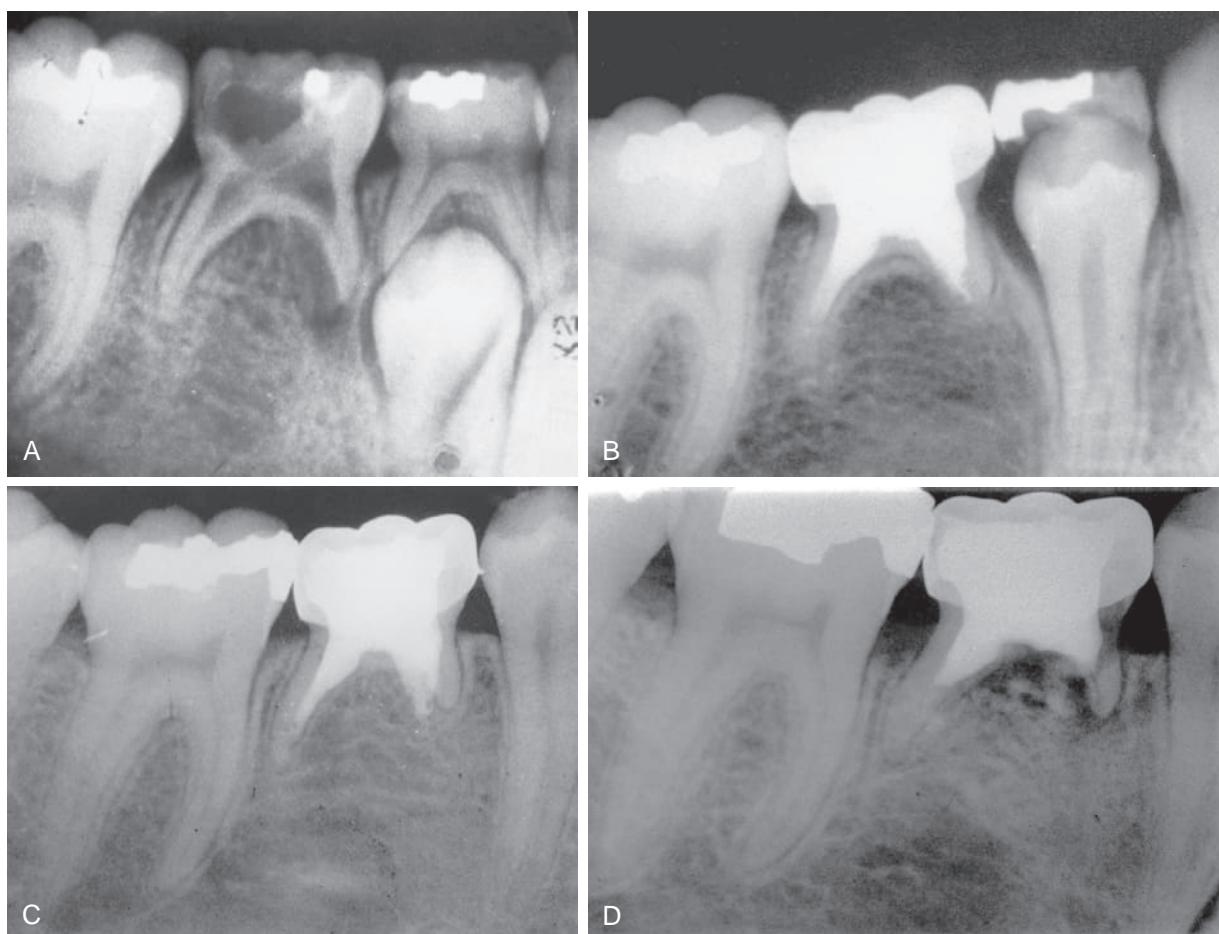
(A) Necrotic tooth resulting from a carious exposure of the pulp of the second primary molar. Because the succedaneous second premolar was congenitally missing, a decision was made to attempt to save the tooth as a functional space maintainer through the growing years, if possible. Note the evidence of internal resorption at the floor of the pulp chamber. (B) Radiograph made 1 year and 7 months after the pulp canals were treated and filled. The mesial canal was treated with complete pulpectomy; the distal canal was treated with partial pulpectomy. (C) Six years and seven months after treatment, the tooth is asymptomatic; the supporting tissues appear normal, but some root resorption has occurred. (D) Fourteen years and six months postoperatively, the tooth was extracted because of the development of symptoms and loss of bone support. At this time, the patient was a young adult, and a fixed bridge was made.
